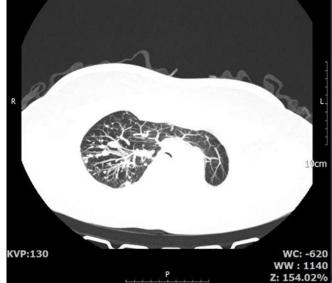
Chest HRCT (2023). Active Tuberculosis with destroyed left lung.
